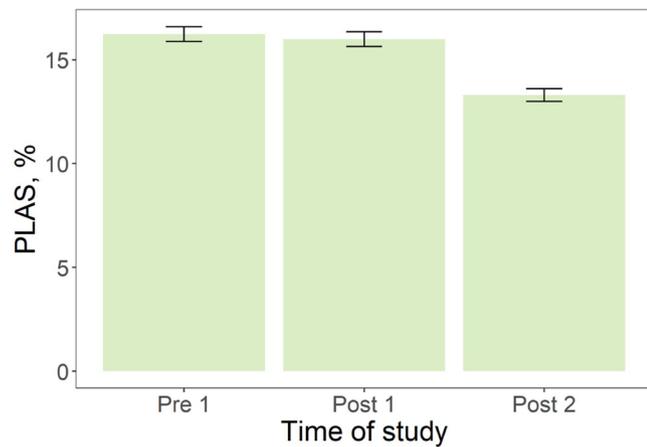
The strain of AF patients ($n = 108$) with two catheter ablations with one MRI before all and one MRI after each ablation. Error bars represent standard error (SE). AF, Atrial Fibrillation; MRI, magnetic resonance imaging.
